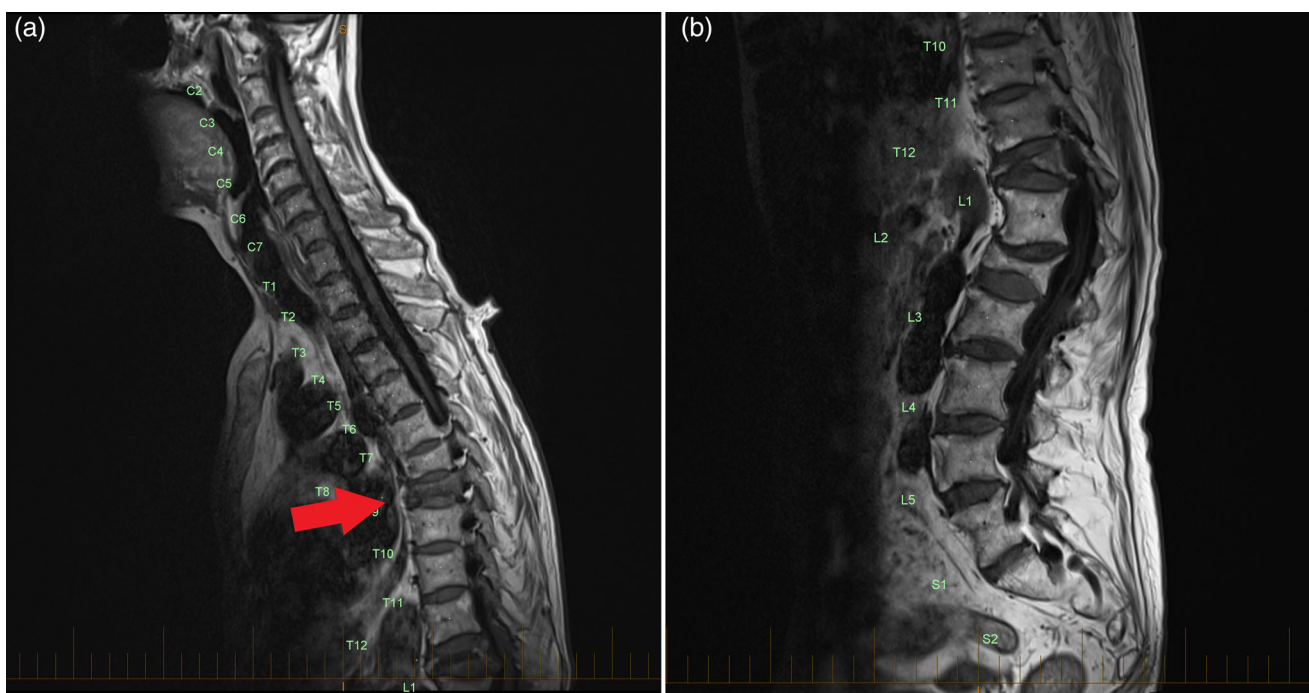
T₁-weighted MRI imaging of the thoracic (A) and lumbar spine (B) showing an acute compression fracture identified in T8 (arrow) and evidence of prior vertebral compression fractures in T7, T12, and L2.
